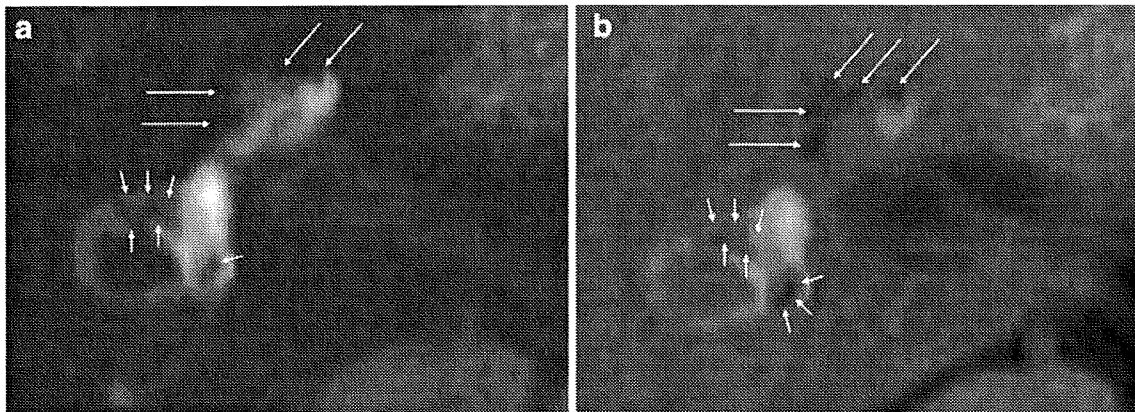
A 31-year-old man with acute low-tone sensorineural hearing loss in the right ear (average, 31 dB). All images were obtained 24 h after the intratympanic injection of Gd-DTPA. (a) 3D-FLAIR (9,000/134/2,500) shows enlarged endolymphatic space in the cochlea (arrows) as low signal areas; however, the boundary between endolymphatic space and surrounding bone is unclear. Mild enlargement of the endolymphatic space in the vestibule (short arrows) is observed. (b) A 3D-real IR sequence (9,000/134/1,700) visualizes severely enlarged endolymphatic space in the cochlea
